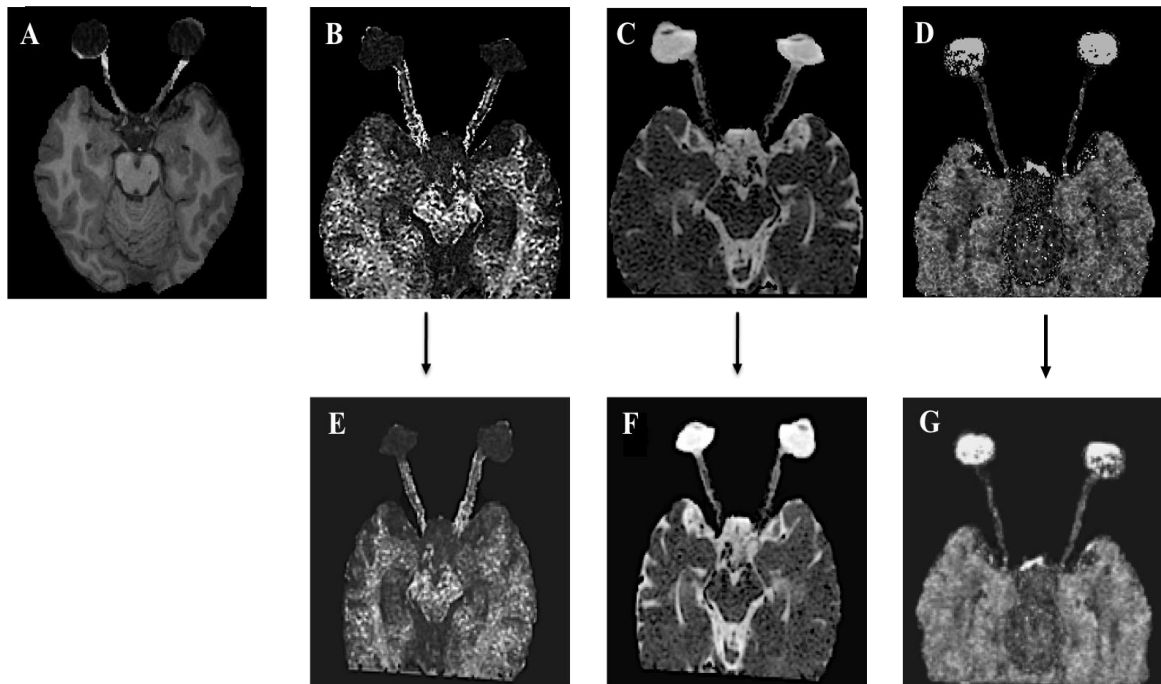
Image registration. Example image registration between different MRI images. Cross-sectional image registration was done for baseline diffusion-weighted images using high-resolution pre-contrast T1-weighted images (A). Raw FA (B), MD (C), ODI (D) maps and registered. Final FA (E), MD (F), ODI (G) maps are shown.
